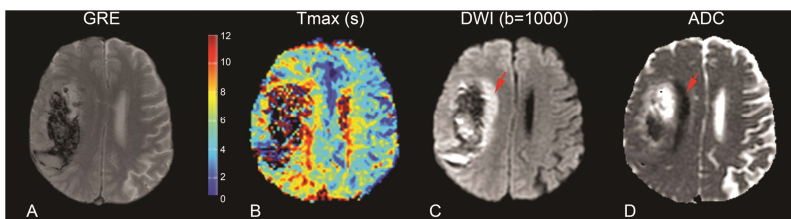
(A) Gradient echo (GRE) MRI showing large lobar hemorrhage, (B) perfusion map ( $T_{max}$ ) showing perihematomal hypoperfusion outside of the hematoma, (C) diffusion weighted image (DWI) and (D) apparent diffusion coefficient (ADC) map demonstrating a sizable perihematomal lesion medial to the hematoma with reduced diffusion (red arrows).
